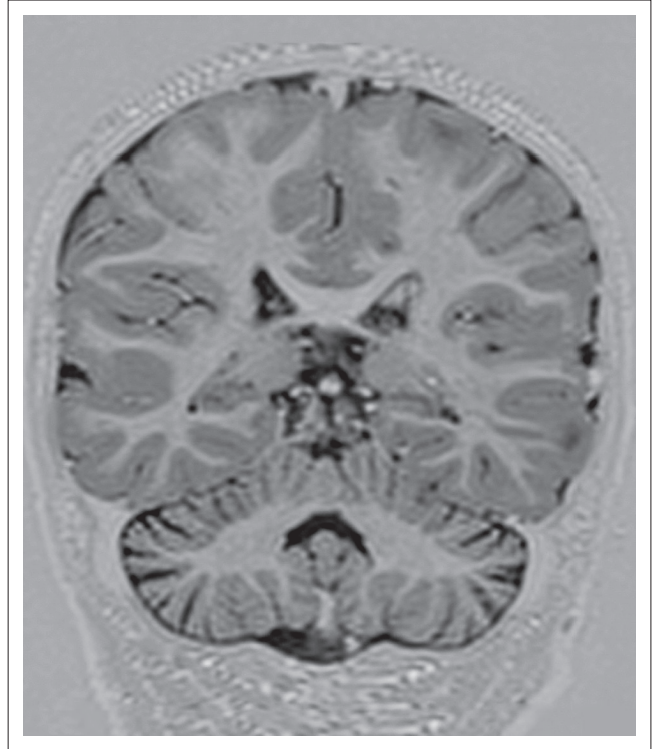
Coronal T1-Inversion Recovery MR image.
